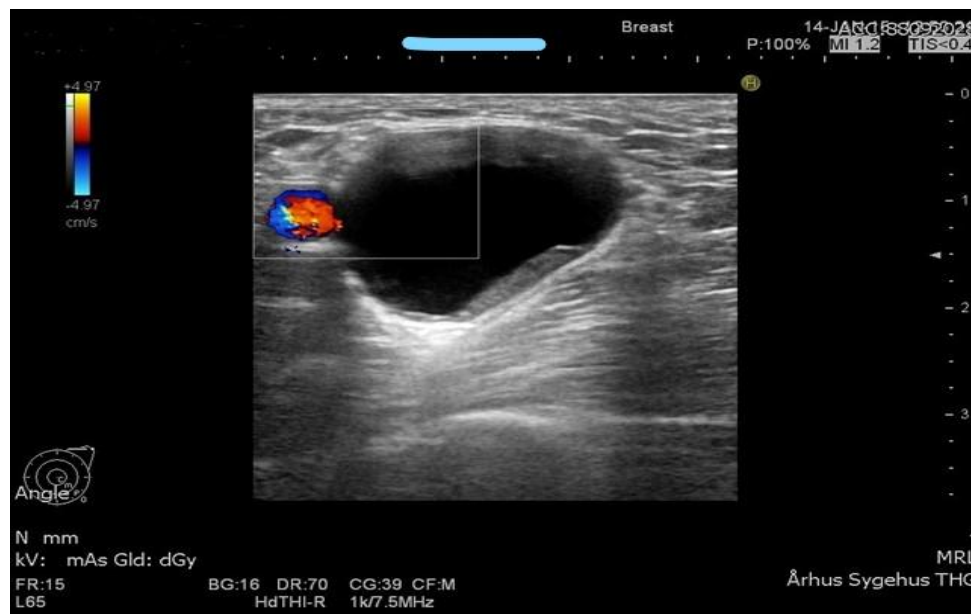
Ultrasound of the left axilla: Oval, cystic lesion, mobile, well defined, measuring 25 mm
